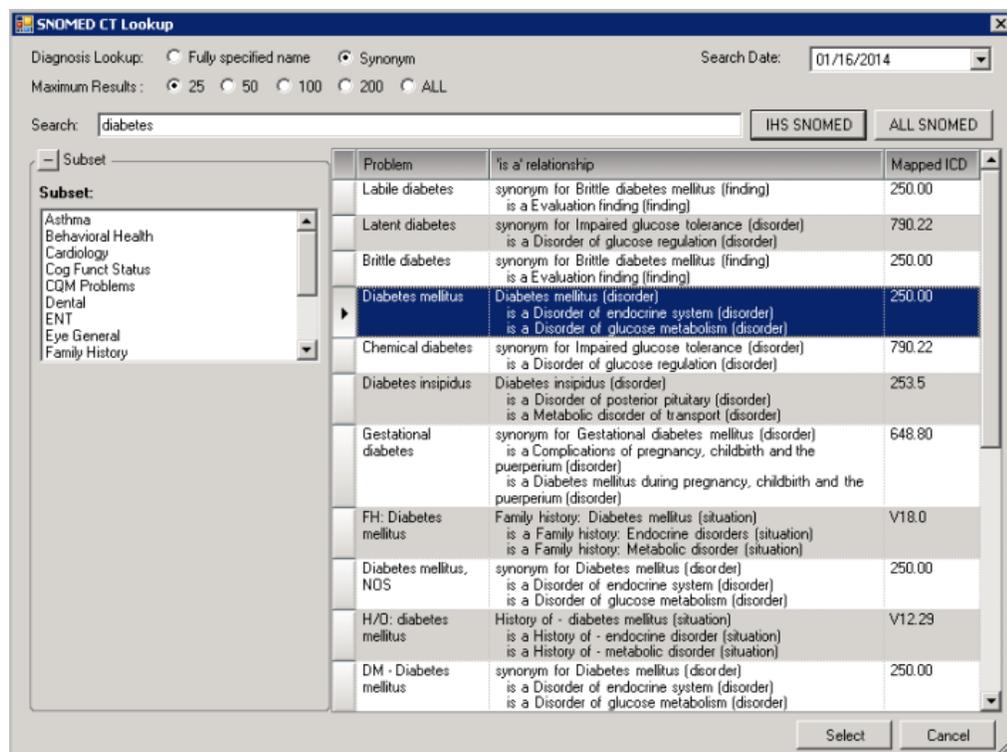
SNOMED CT Lookup dialog
